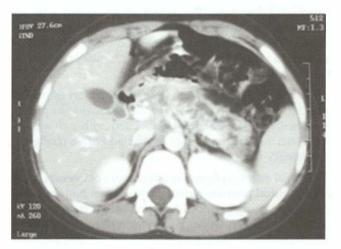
CT scan showing dilated main pancreatic duct in chronic pancreatitis
